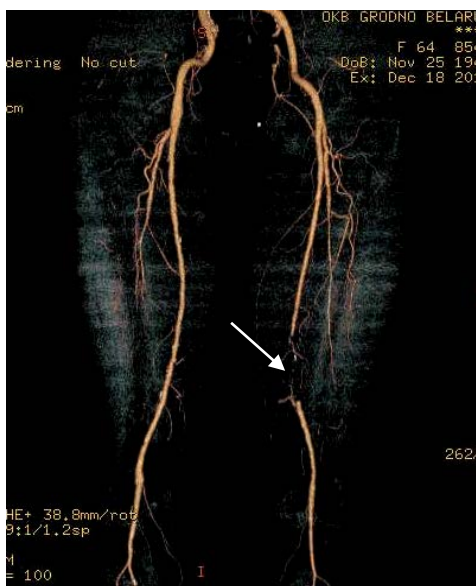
Multi-slice spiral computed tomography – volume rendering. Frontal view. Three-dimensional reconstruction arteries hips. On the left is absent the image distal part of superficial femoral artery because of it occlusion (arrow). Occlusion of the left superficial femoral artery
